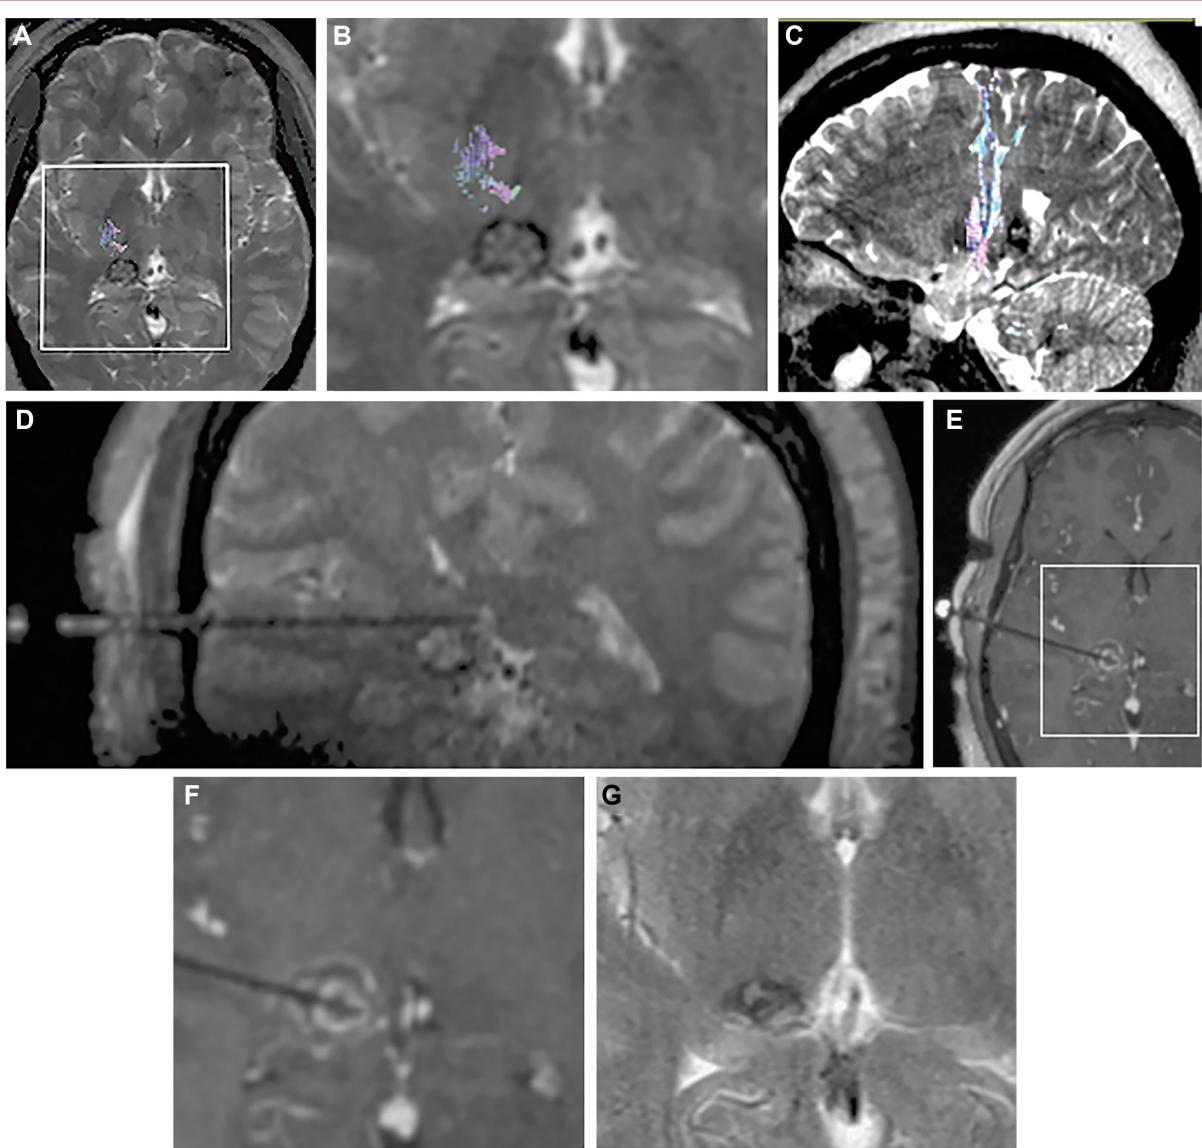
Ablation of CCM of right pulvinar in patient 1. A, Preoperative axial T2-weighted image of mixed-intensity lesion with overlaid postprocessed motor tractography (colored) derived from diffusion tensor imaging (DTI), which was seeded from the location of blood-oxygen-level-dependent (functional) MRI during left hand movement. The content of the white box is magnified in B to emphasize posterior location of lesion relative to primary motor pathways. C, Preoperative sagittal T2-weighted image with tractography again showing position of lesion relative to motor pathways (colored). D, Intraoperative paracoronal T2-weighted image showing initial superior deflection of laser probe (linear low intensity) placed by Cosman-Roberts-Wells (CRW) headframe (Integra Neurosciences Inc). E, Intraoperative gadolinium-contrasted axial T1-weighted image showing correct placement of probe into the lesion using an MRI-guidance platform following initial ablation. This image demonstrates postablation contrast enhancement reflecting early post-LITT changes and is magnified in F, which corresponds to the analogous axial section and magnification A and B. Tissue changes take time to observe and can be seen in G, a follow-up axial T2-weighted image at 14 mo at same magnification as B and F demonstrating evidence of partial involution.
